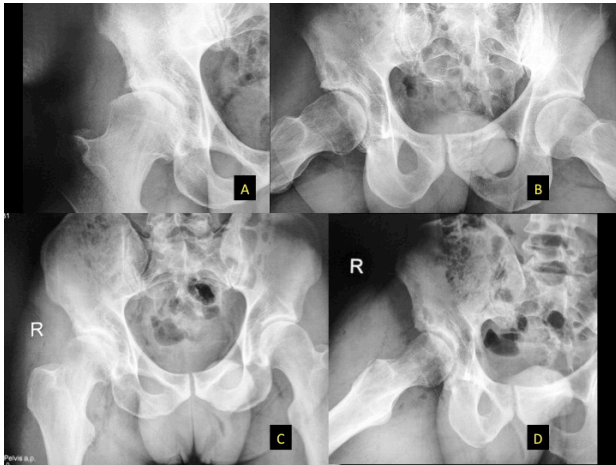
X-ray of a case with Tönnis I. A: Frontal view with slight narrowing of femoroacetabular space. B: Axial view with abnormal alpha angle. C and D: Frontal and axial postoperative view with correction of impingement and alpha angle corrected.
